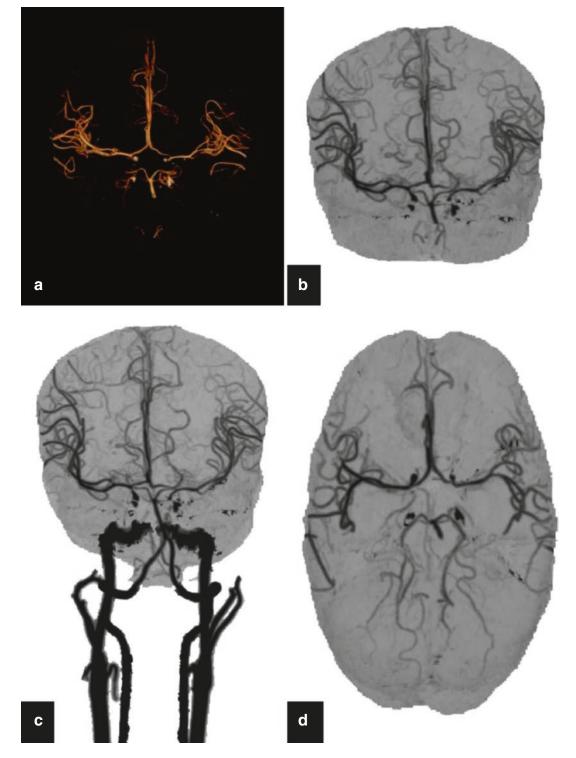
CT angiography of the brain in a patient with TBM depicts severe stenosis of distal ICA leading to its non-visualization; the anterior and the posterior circulation are seemingly independent (a–d)
